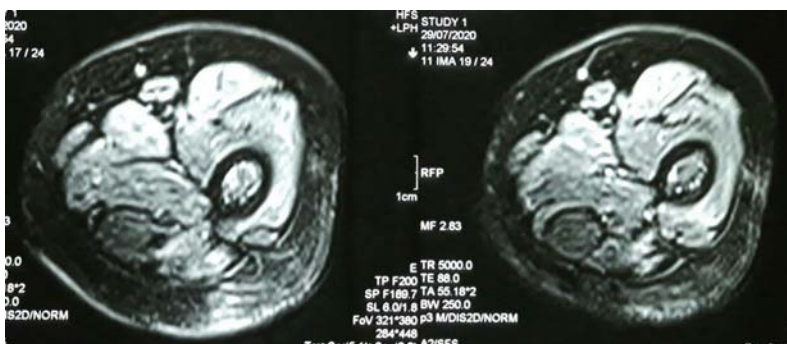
MRI Thigh suggestive of myositis
